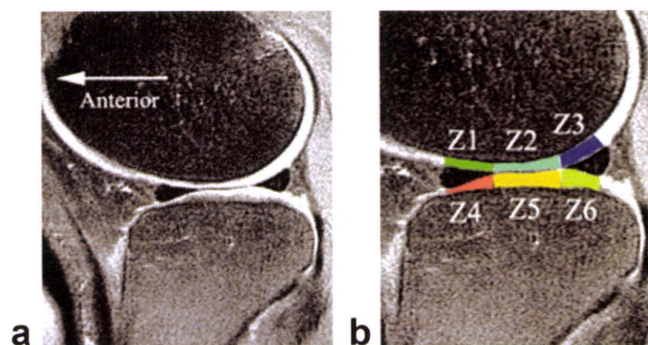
(a) Representative sagittal MR image (1500/15) of the lateral femoral-tibial joint, and (b) definition of regions of interest (ROIs) in the femoral and tibial cartilage in the weight-bearing area.
